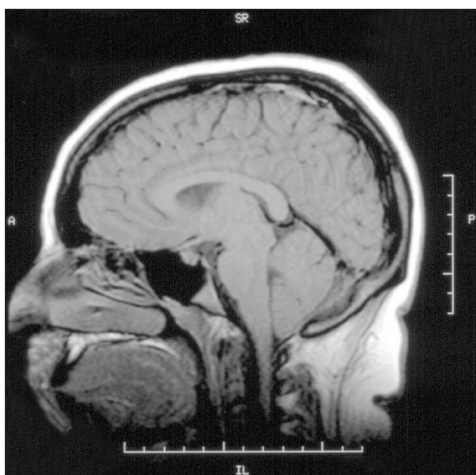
Normal sagittal view of the patient's cranial MRI at initial diagnosis of pseudotumor cerebri
